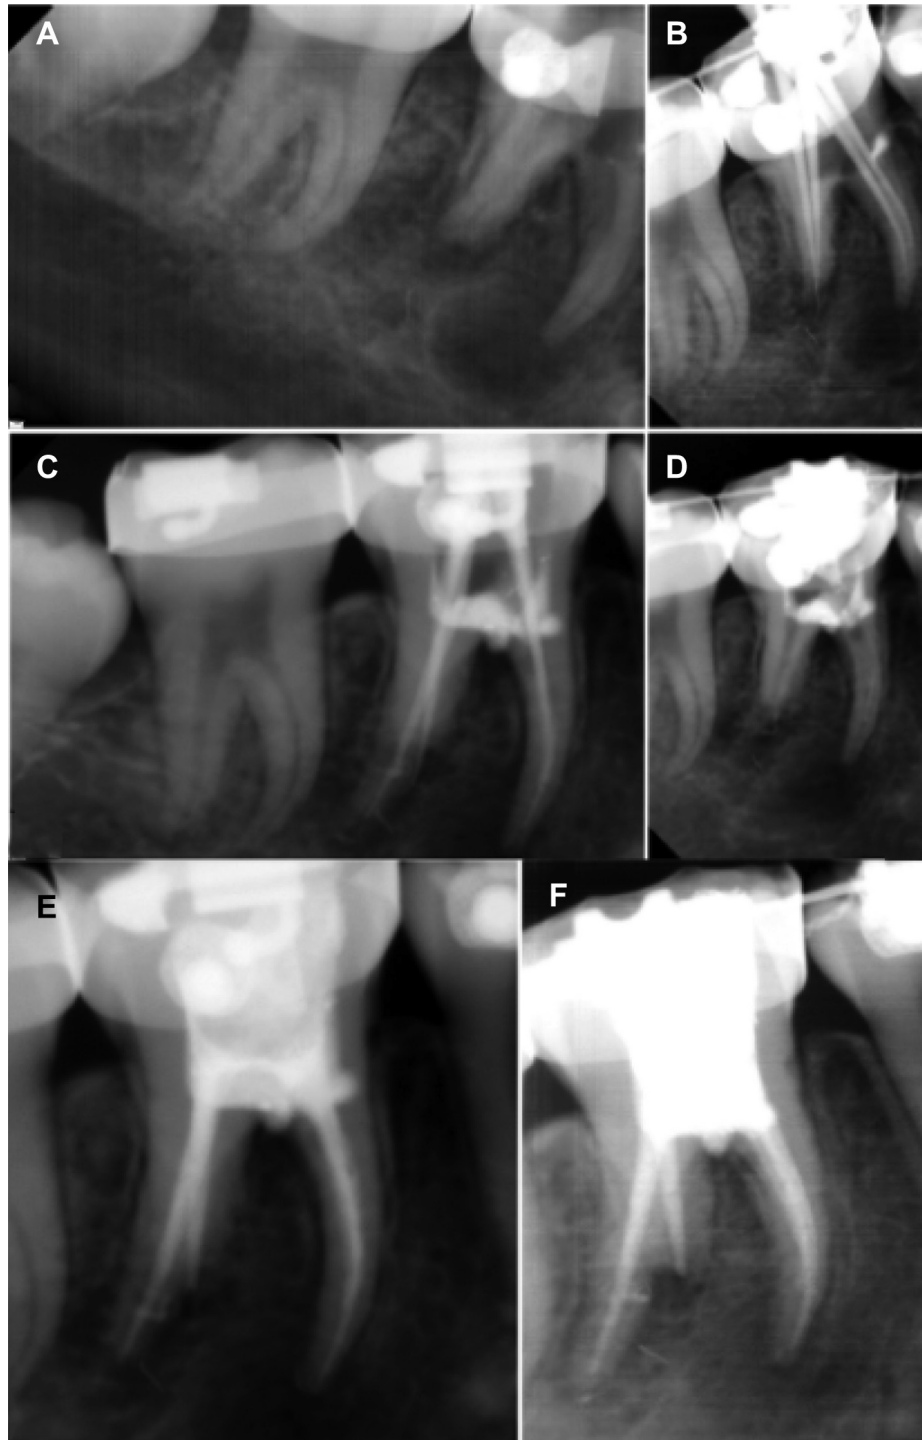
(A). Pre-operative radiograph. (B). Cocoa butter coated GP points placed in pre-flared canals. (C). MTA placed in the furcal perforation site. (D). GP points removed after 24 h. (E). Immediate post-obturation radiograph. (F). Radiograph after six months showing periapical and furcal healing.
